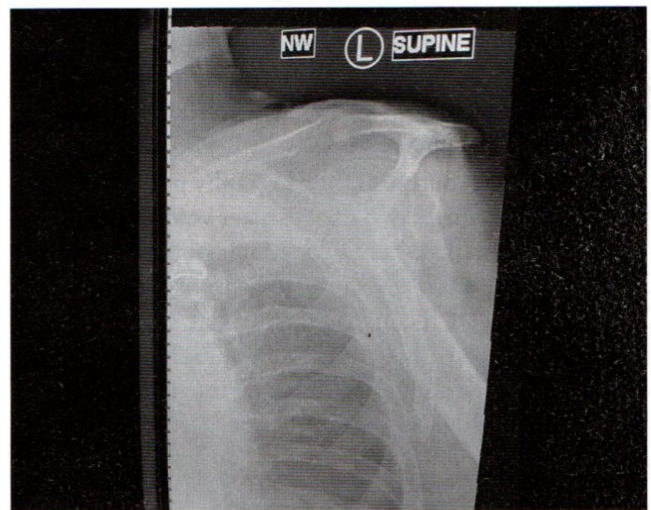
A digital radiograph obtained using the Wolfrum method for recumbent Y-shoulder imaging. Image courtesy of Lehigh Valley Health Network, Pocono, East Stroudsburg, Pennsylvania.
